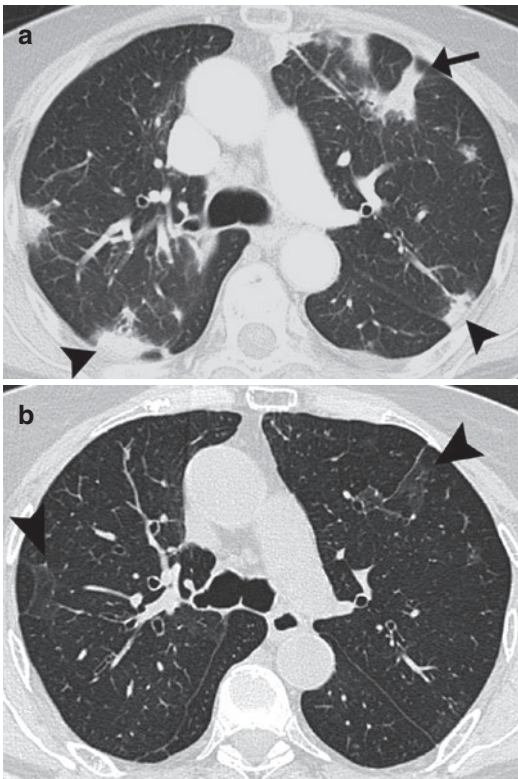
Axial CT image in a 75-year-old woman with COP shows bilateral, peripherally located patchy lung consolidation (*arrowheads*). In one of the lesions, the subpleural space is typically spared (*arrow*) (a). Follow-up CT image obtained after 4 weeks of corticosteroid therapy shows subtotal resolution of the lung abnormalities with residual ground-glass opacities (*arrowheads*) (b)
